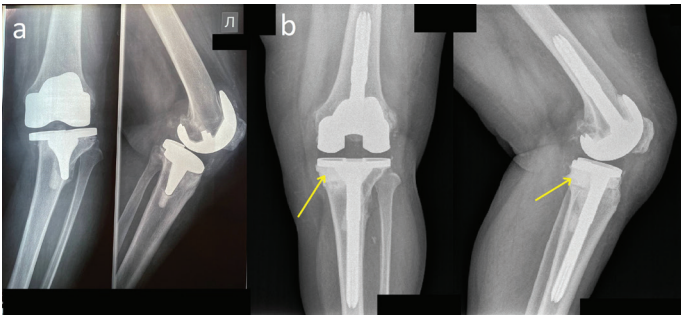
Radiographs of the knee joint (a) - preoperatively, instability of both endoprosthesis components and migration of the tibial component are identified; (b) - postoperatively, the fitted endoprosthesis and cement augmentation are identified (indicated by arrows)
